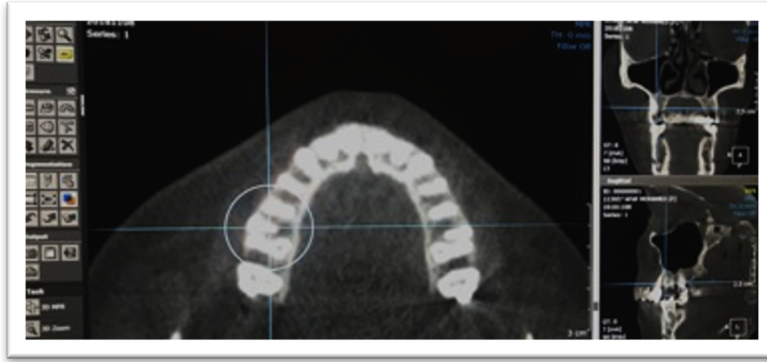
CBCT images demonstrate Mesio Buccal root with 2 canals as viewed in axial, coronal and sagittal directions.
